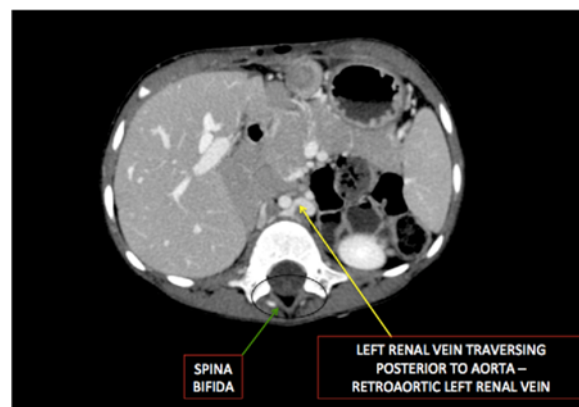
Contrast enhanced CT scan (axial image) shows spina bifida (black circle). The left renal vein is traversing posterior to aorta, suggestive of retro-aortic left renal vein.
